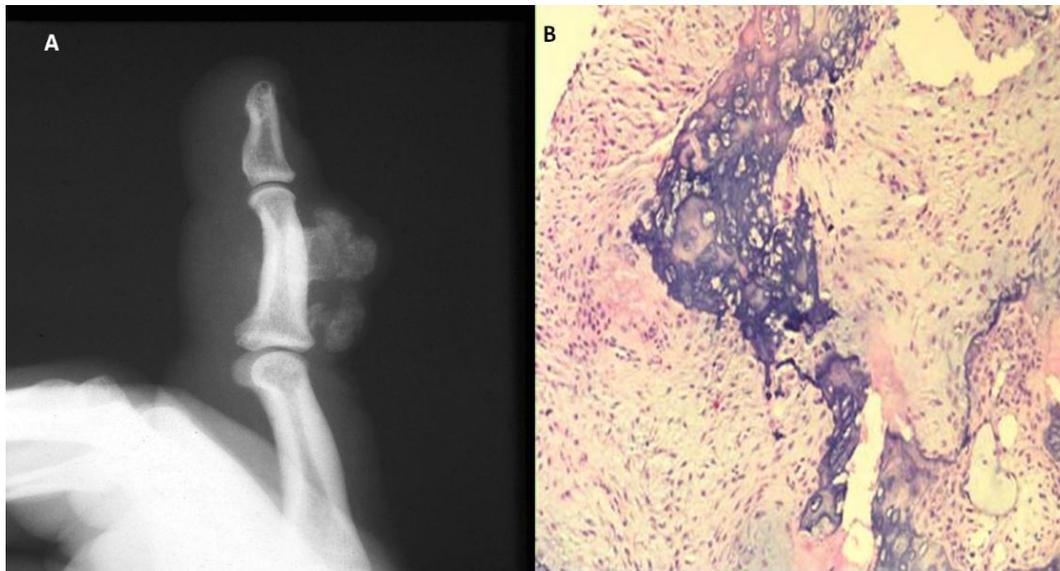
On right side, a radiograph showing a bony nodule on the ulnar aspect of her distal fifth metacarpal while on left side an admixture of cartilage, loose fibrous tissue and bone formation.
